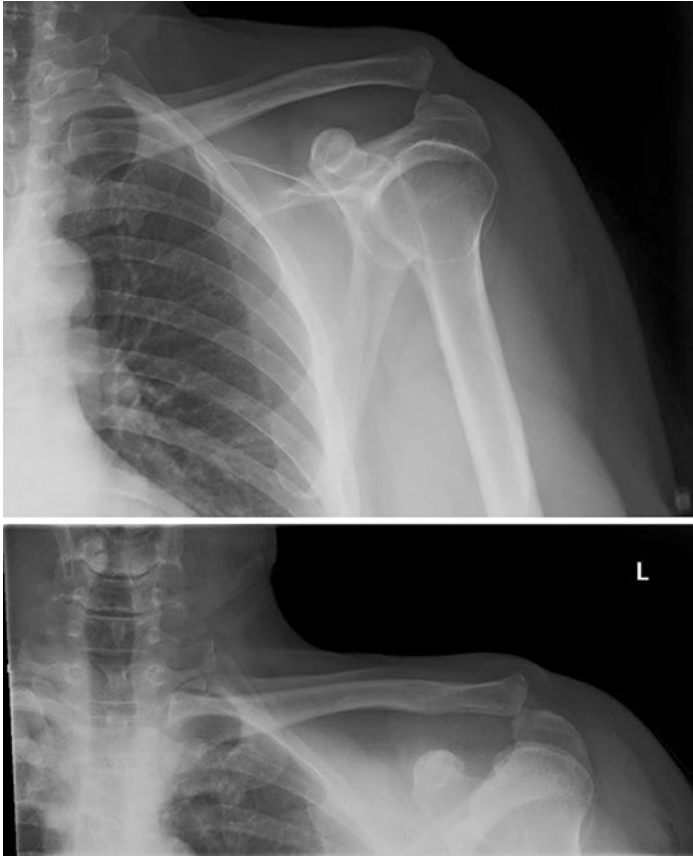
X-rays of the left clavicle
